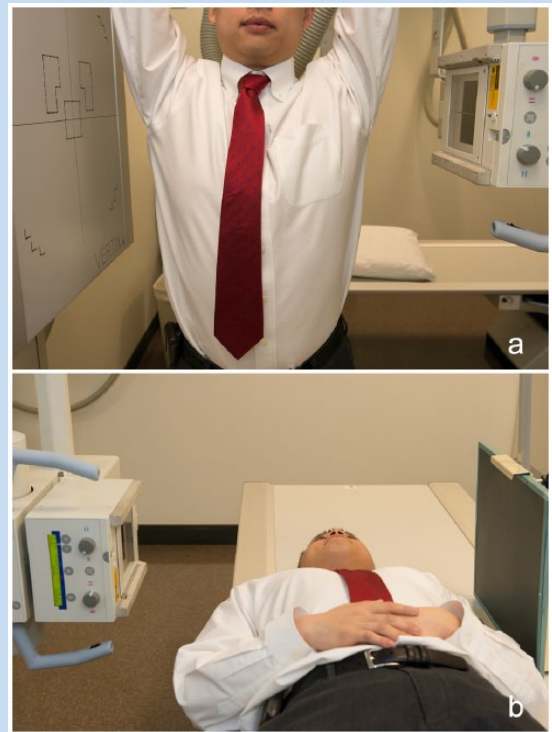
Heilig views. (a) The standing Heilig view is obtained by having the cassette placed perpendicular to the contralateral shoulder with the x-ray beam tangential to the ipsilateral SC joint and parallel to the opposite clavicle, centered to the manubrium. (b) The modified Heilig view is obtained in a similar fashion except that the patient lies supine.
